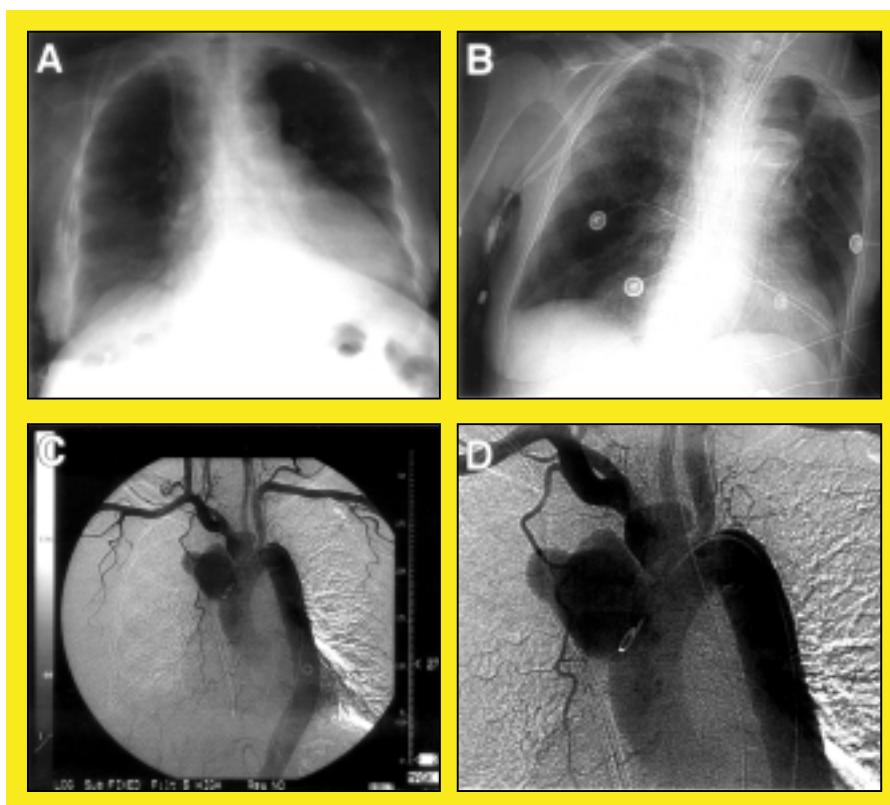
Results of diagnostic procedures on a patient presenting with chest pain, dyspnea, cough, and hemoptysis. (A) Radiography depicting mild left ventricular enlargement with an unfolded aorta causing mediastinal widening; no pulmonary abnormalities are noted. (B) Right upper lobe infiltrate consistent with hemorrhage. (C, D) Aortography revealing a large lobulated pseudoaneurysm of the ascending aorta together with a smaller aneurysm of the transverse arch.
